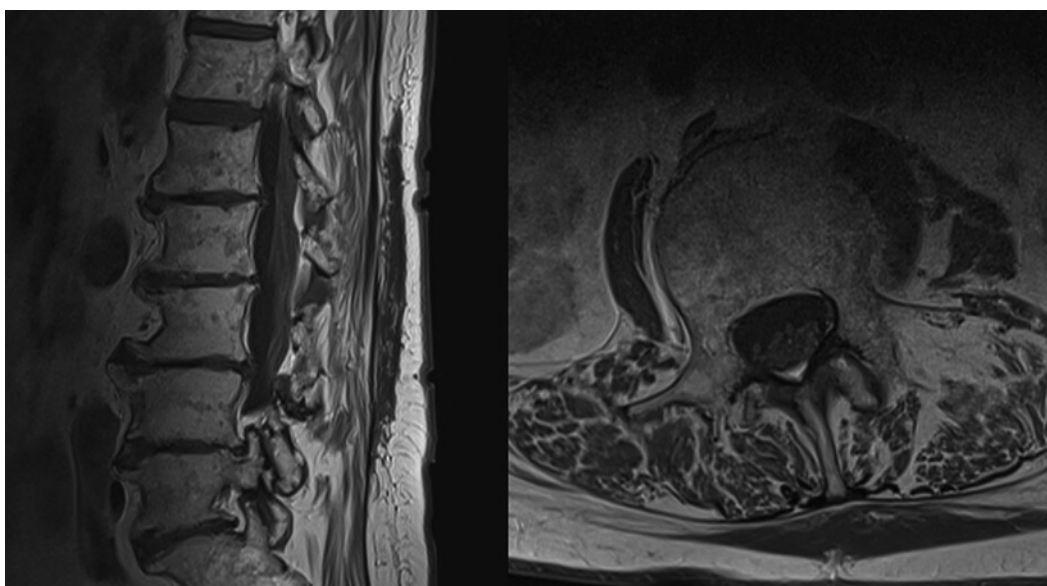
Sagittal and axial images from the MRI of thoracolumbar spine at the 3-week follow-up (contrast-enhanced T1-weighted sequence without fat suppression), showing resolution of the previous contrast-enhancement. The axial image is at the level of the L2 vertebral body.
